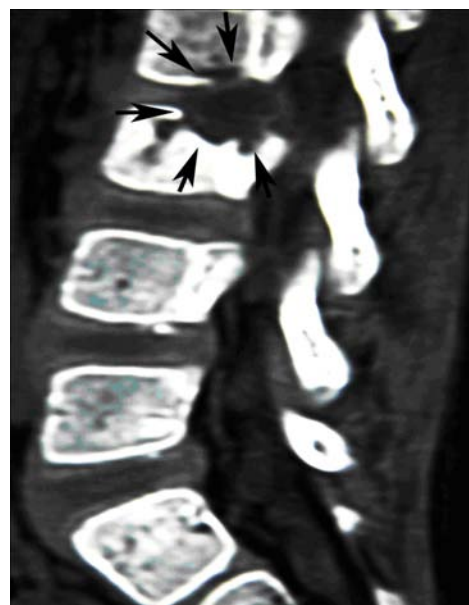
CT scan with 2-dimensional reconstruction showed the osteolytic destruction. The lesion has involved the L2/3 disc.
